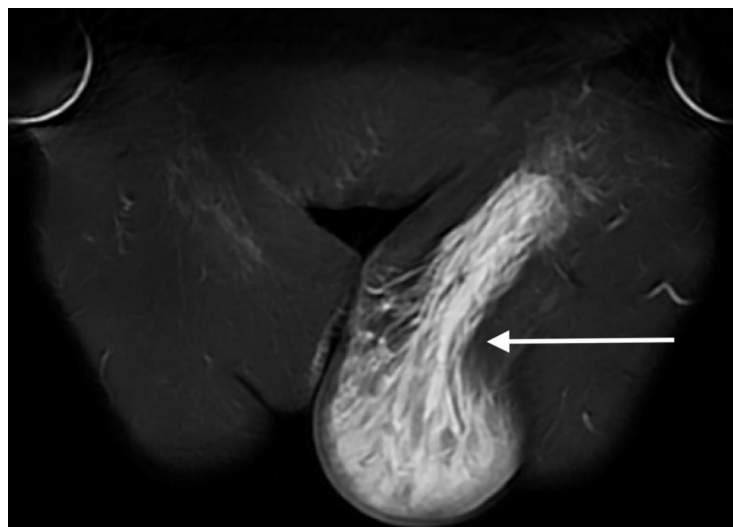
Coronal STIR MRI image, showing the internal fibrillary “lace-like” component (white arrow)
